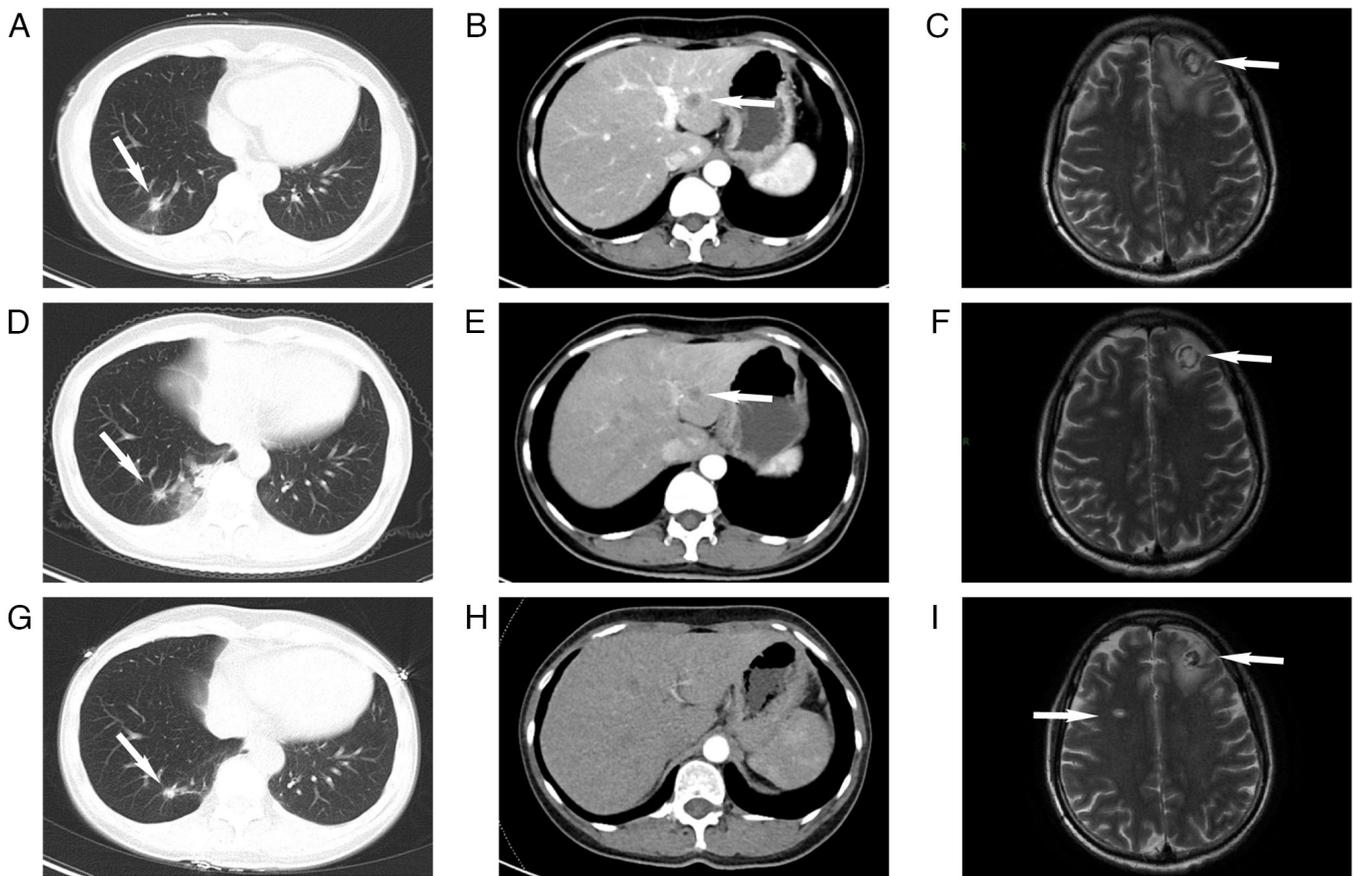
Patient imaging after targeted therapy. After oral administration of crizotinib for 1 month, (A) Chest CT image showing the right lower lobe nodule (arrow) had decreased in size to $\sim 14 \times 11$ mm. (B) Abdominal CT image showing a reduction in the size of the left hepatic lobe nodule (arrow), with a diameter of ~ 14 mm. (C) Brain MR image showing the left frontal lobe lesion (arrow) no significant change. After oral administration of crizotinib for 3 months, (D) Chest CT image showing the right lower lobe nodule (arrow) had decreased in size to $\sim 12 \times 11$ mm. (E) Abdominal CT image showing the left hepatic lobe nodules (arrow) was reduced in size, with a diameter of ~ 10 mm. (F) Brain MR image showing the left frontal lobe lesion (arrow) no significant change. After oral administration of crizotinib for 9 months, (H) chest CT image showing a further reduction in the size of the right lower lobe nodule (arrow), with resulting size of $\sim 8 \times 9$ mm. (I) Abdominal CT image showing the left hepatic lesion had disappeared. (G) Brain MR image showing a slight increase in the number of lesions in the bilateral parietal lobes (arrow). CT, computed tomography; MR, magnetic resonance.
